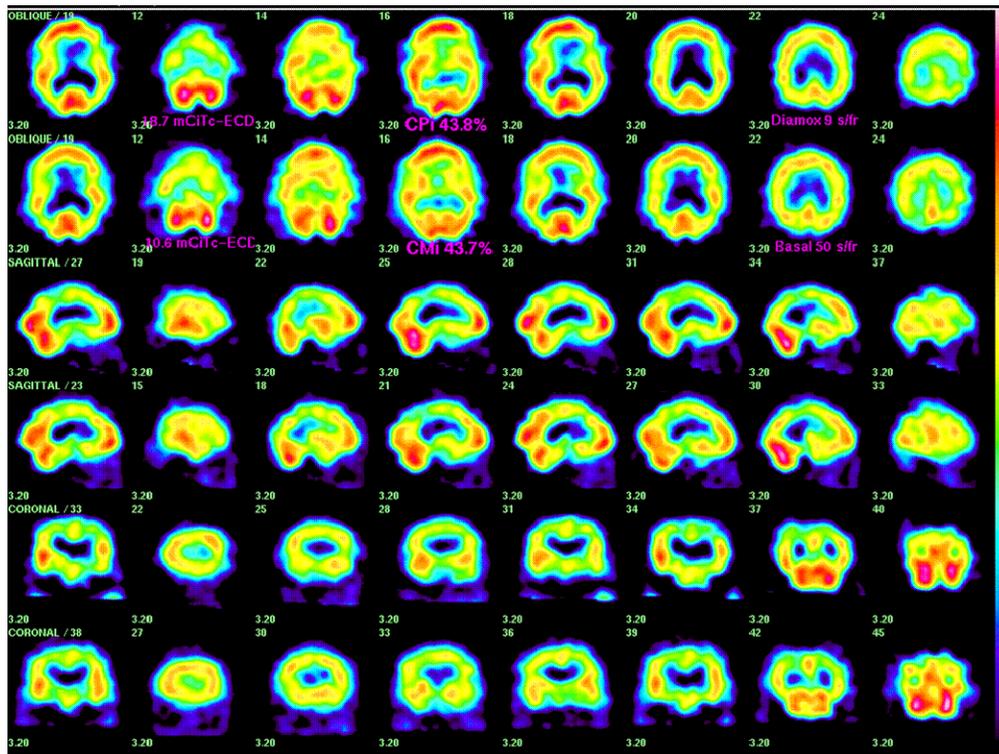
(above) An 86 year-old hypertensive man (initial untreated BP at age 84 yrs was 174/94) with short-term memory loss had rapid protocol Brain SPECT shown to the right. Tc-99m-ECD behaves as a perfusion tracer during the initial approx 3 min and has stable Cerebral activity after 1 min allowing a rapid perfusion SPECT (Top of each of 3 paired rows of images). After 40 min the pattern from the same tracer is dominated by energy-dependent metabolic fixation of the tracer (Bottom of each of 3 paired image rows). This is an example of regional decrease in CPi in the parietal cortex, which, if more prominent, would result in negative CFi (cf. key concept 4 above).
